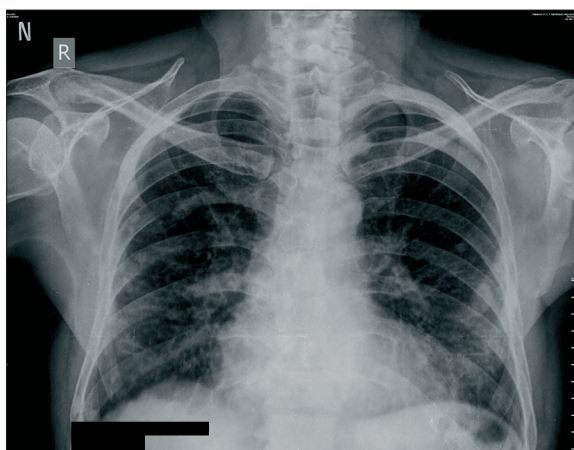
Chest X-ray after 6 months of therapy.
